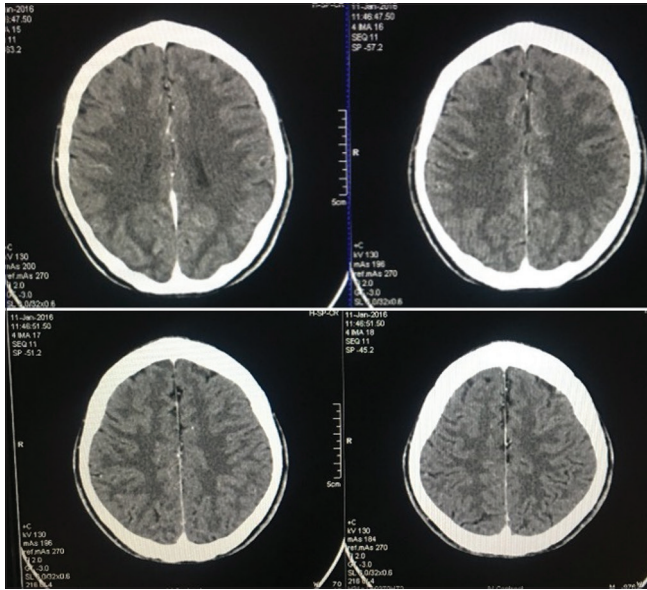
Repeat cranial computed tomography showed complete resolution of the ring enhancing lesions after 8 weeks of the treatment.
